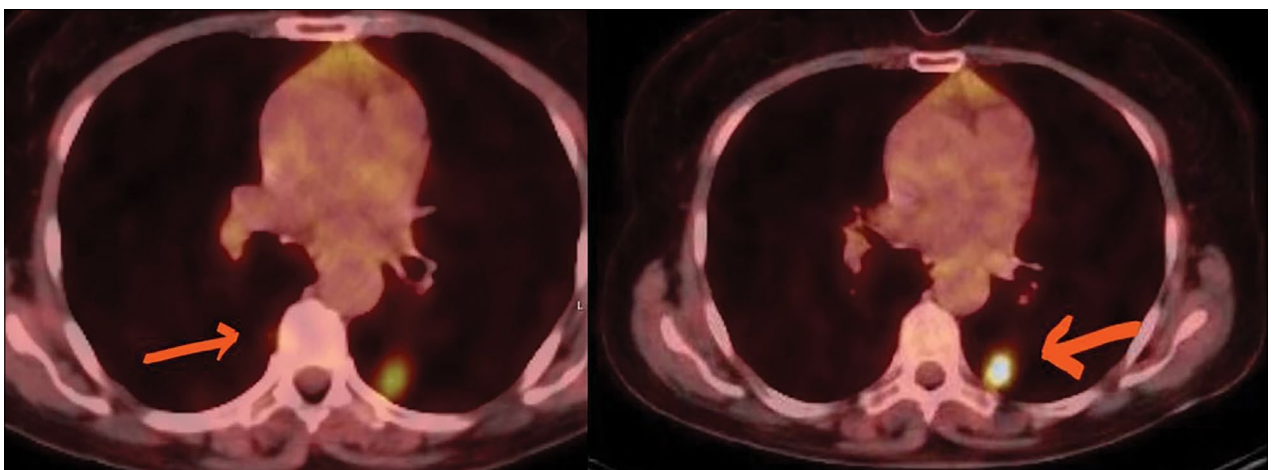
Both of the nodules are hypermetabolic (left upper lobe nodule SUVmax: 13.7, right lower lobe nodule SUVmax: 2.7) on PET CT.
